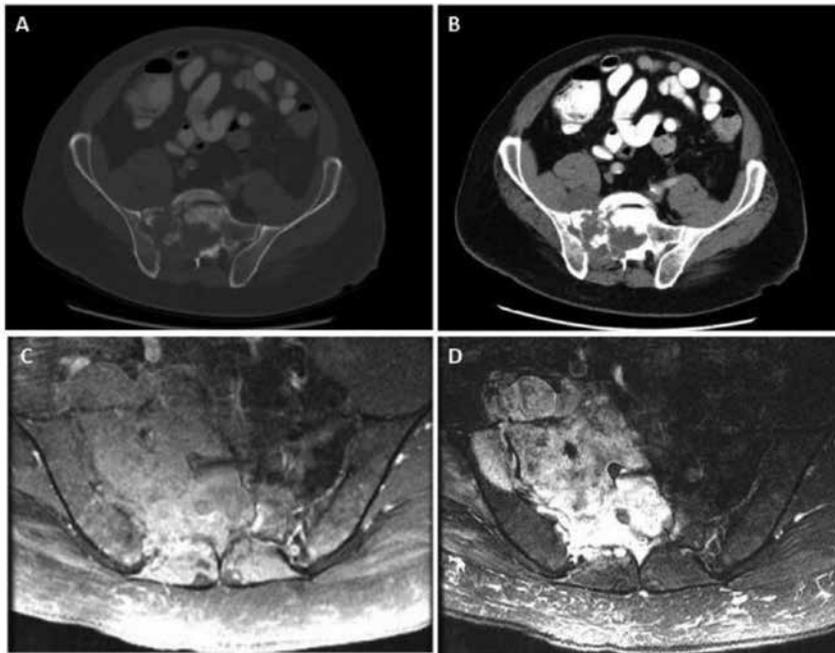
Initial presentation of chordoma. Imaging on initial presentation demonstrated an 8.6 x 6.1 x 7.7-cm lytic lesion centered at the right sacrum and invading the cauda equina with pathologic fracturing of the right hemisacrum and right iliac bone. A) axial CT image centered on tumor on bone window, B) axial CT centered on tumor on soft tissue window, C) axial T1-weighted fat-suppressed postcontrast MRI image of tumor, D) axial T2-weighted fat-suppressed MRI image of tumor.
